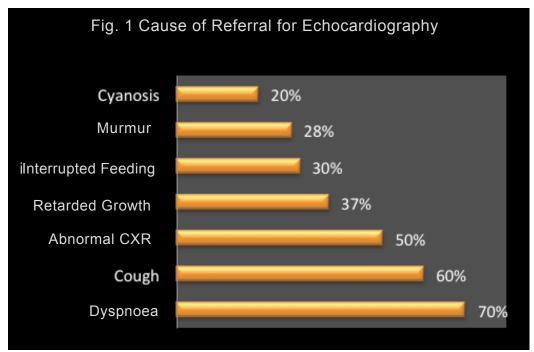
Cause of referral for echocardiography and including symptoms and signs in 180 cases.
